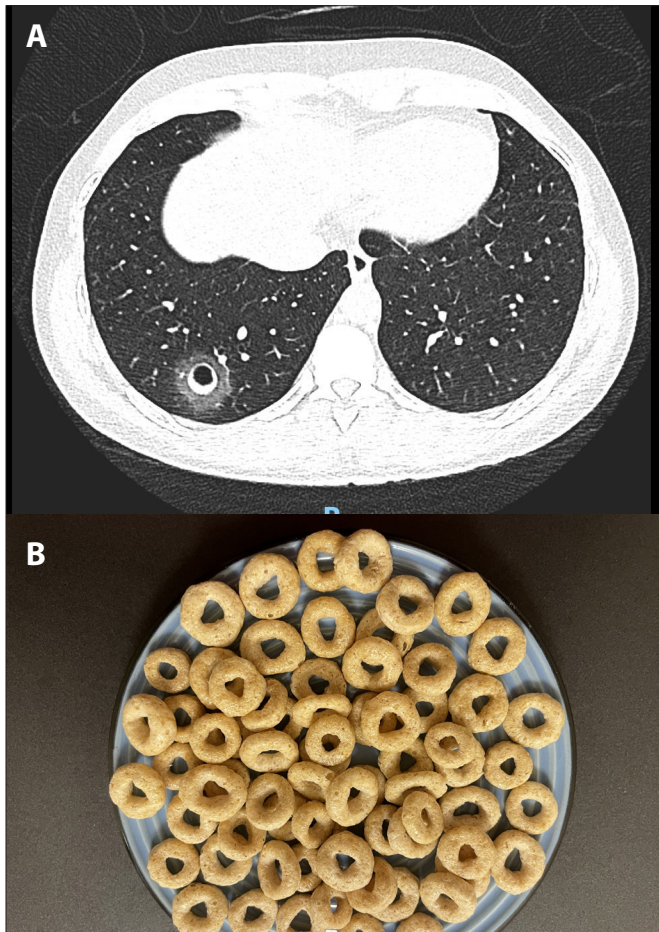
(A) High-resolution computed tomography showing the Cheerios sign: a nodule with a central lucent cavity and surrounding ground-glass rim in the right lower lobe. (B) Cheerios breakfast cereal.
